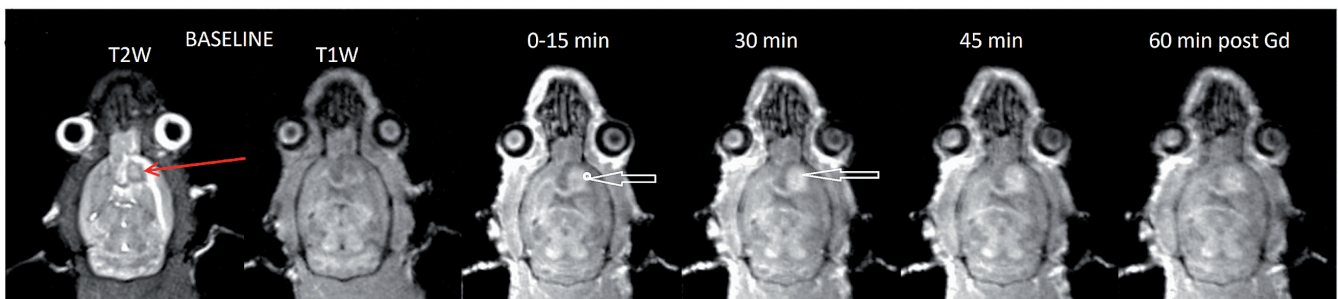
Progression of MRI signal following intraperitoneal administration of contrast agent. White arrows: The diffuse bright spot (white arrow) indicates evasion of Gd contrast agent predominantly at the margin (15 min), which is the distributed of the tumor (30 min), but not into the surrounding edema (hyperintense on T2w, hypointense on T1w). The later time points indicate the clearance of Gd.
